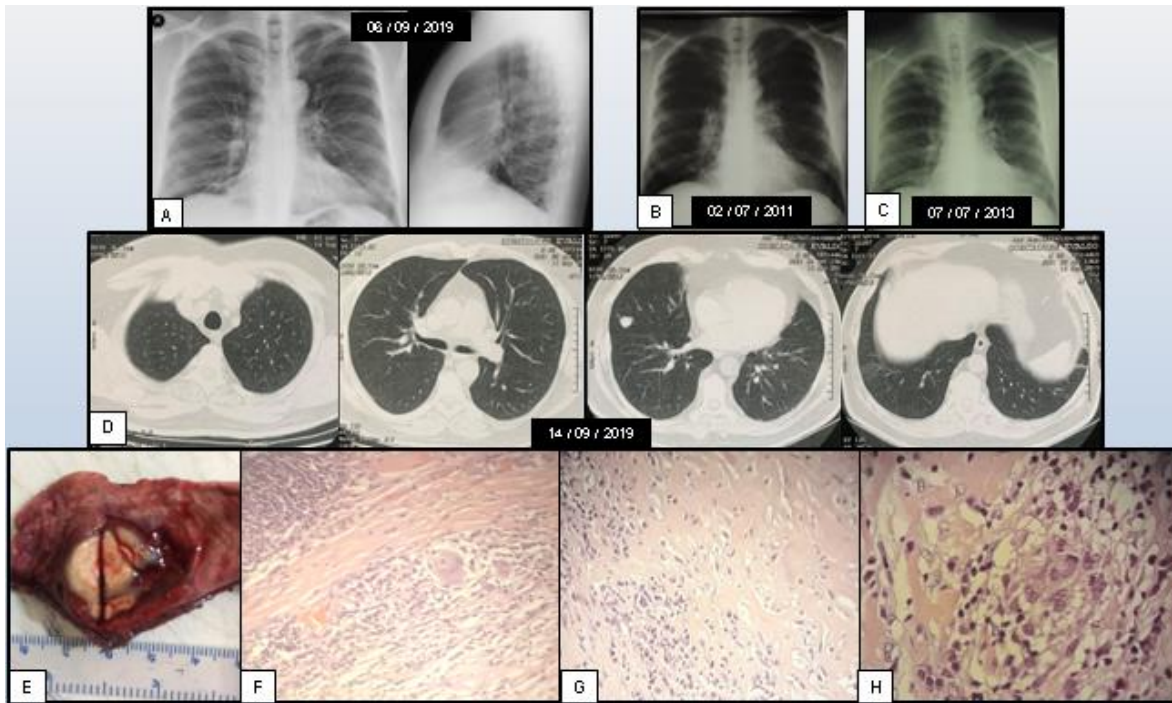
A) 2019 thorax X-ray showing a nodular lesion in the right lower lobe; B) 2011 thorax X-ray showing bilateral hilar lymphadenopathy; C) 2013 thorax X-ray showing bilateral hilar lymphadenopathy regression; D) 2019 Thorax High Resolution Computed Tomography study; E) Nodular fragment of lung tissue with a smooth white lesion; F) Encapsulated area of granulomatous inflammatory process with multinucleated giant cell presenting an asteroid body; G) Fibrinoid necrosis; H) Granuloma with epithelioid cells.
